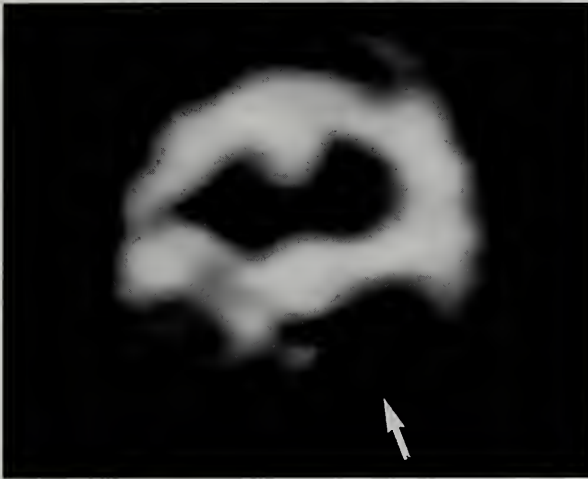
Interictal HMPAO SPECT of this patient (A) showed decreased perfusion in the left temporal lobe (arrow) confirming the left temporal focus determined by depth electrode recordings. The corresponding post-ictal SPECT was normally to hyper-perfused in the left temporal lobe (arrow) in this case.
